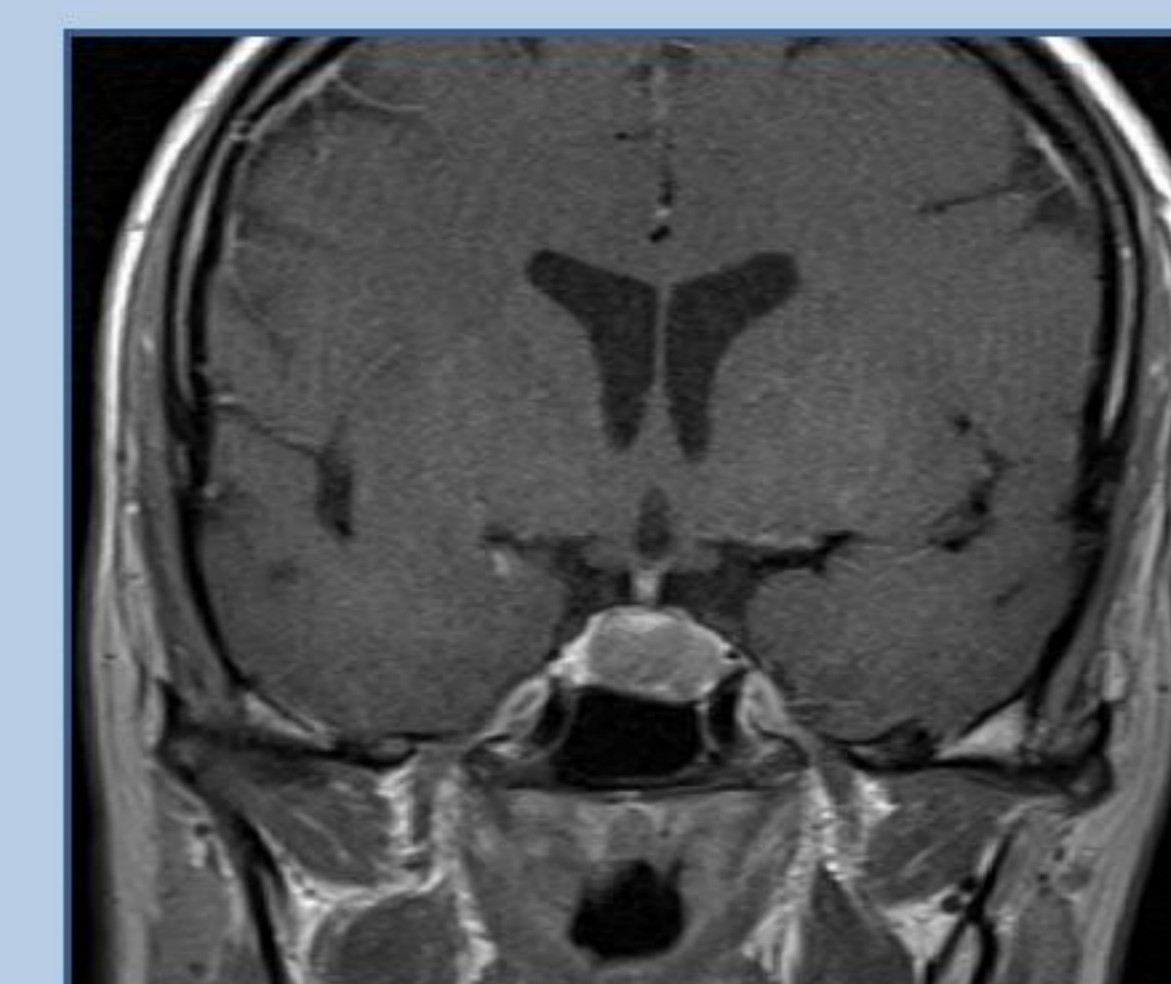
Pituitary MRI: regression of pituitary hyperplasia
